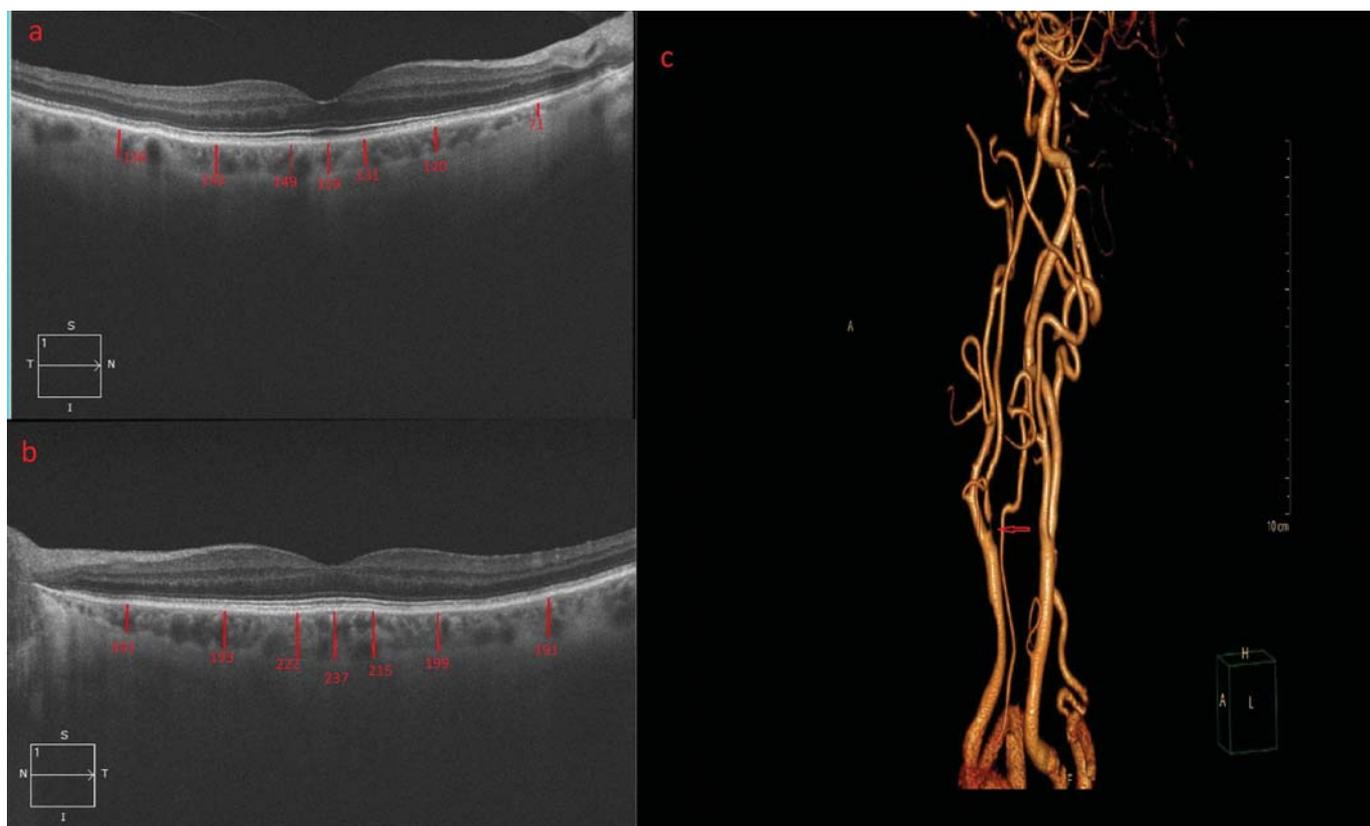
Choroidal thickness measurement at central subfoveal, 500-1500-3000 μm temporal to the fovea and 500-1500-3000 μm nasal to the fovea in the right eye of a patient with ipsilateral >95% ICA stenosis. 1b; EDI-OCT image of the left eye of the same patient with ipsilateral 20% ICA stenosis. 1c; 3D Carotid artery computed tomography angiography image of the same patient. Red arrow demonstrates >95 % right ICA stenosis.
